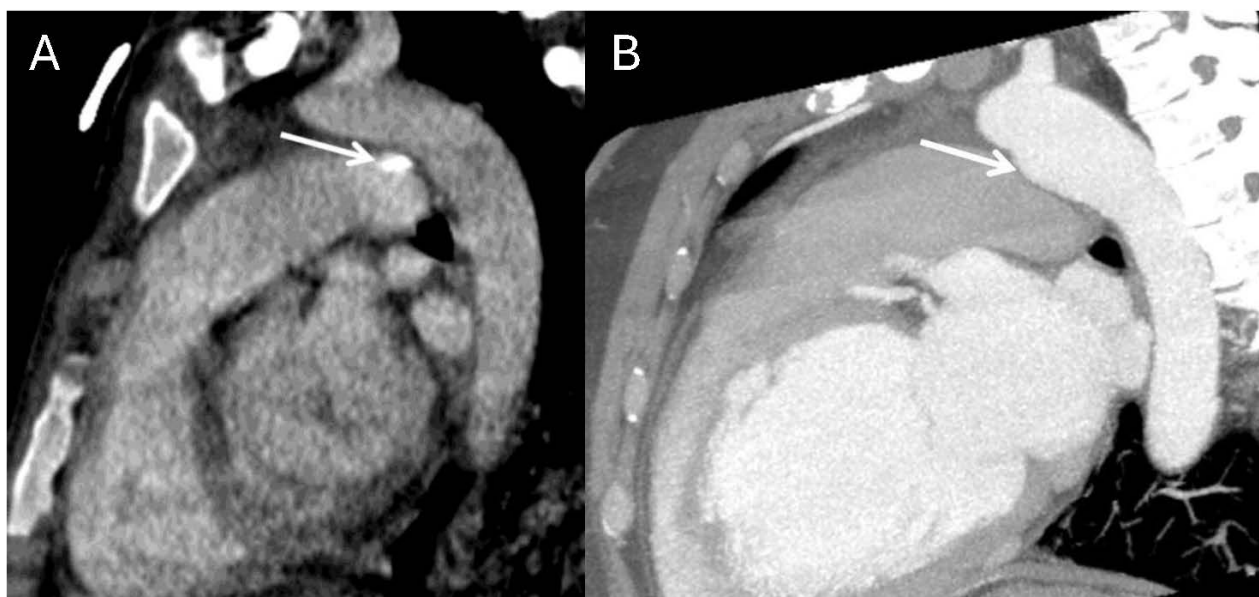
Normal anatomic variants that may mimic PDA on imaging. (A) Contrast-enhanced chest CT with oblique reformatting reveals calcification of the ligamentum arteriosum at its typical location between the aortic isthmus and proximal left pulmonary artery. (B) Contrast-enhanced chest CT with oblique reformatting in a different patient shows a ductus diverticulum (arrow), representing a residual aortic outpouching that occurs when the ductus arteriosus undergoes its normal closure pattern beginning from the pulmonary arterial end [77].
